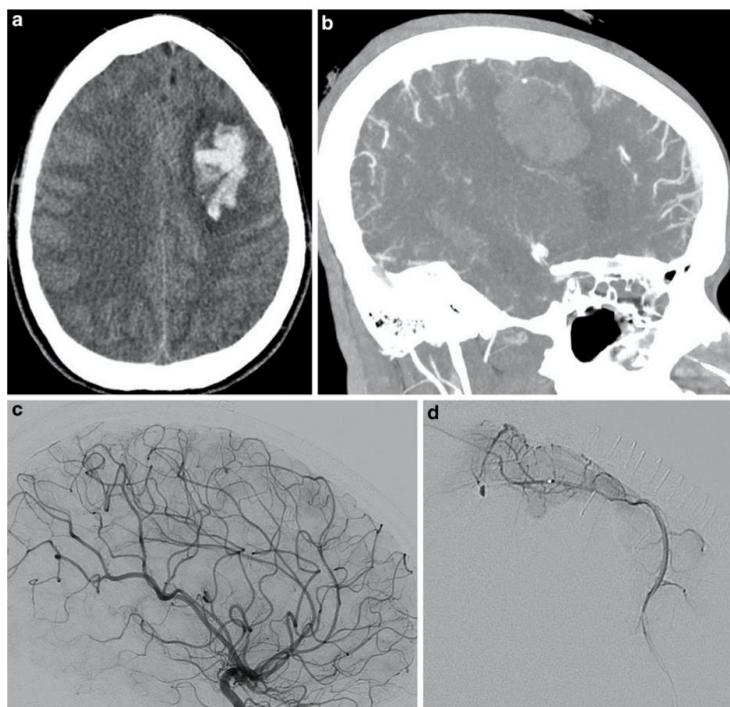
Images from patient 6, clockwise from top left: a non- contrast CT showing a left frontal parenchymal hematoma. There was also intraventricular extension (not shown). b Sagittal maximal intensity projection (MIP) from CTA showing a spot on a string (SOAS) sign coursing along the edge of the hematoma. c, d Left ICA injection, lateral view (c), and magnified microcatheter injection s(d) of the left callosomarginal artery in the same projection, showing the aneurysmal segment of the vessel more distally, with some contrast medium stagnation within it.
